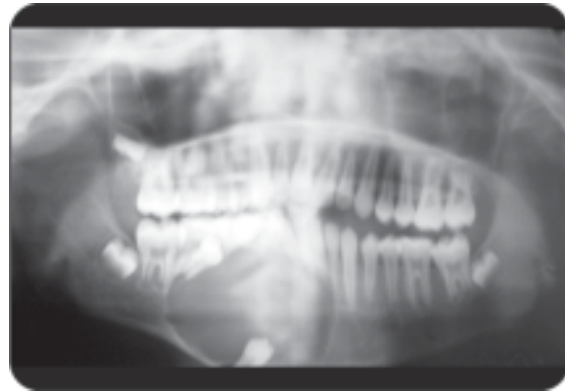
Radiograph of calcifying epithelial odontogenic tumor
